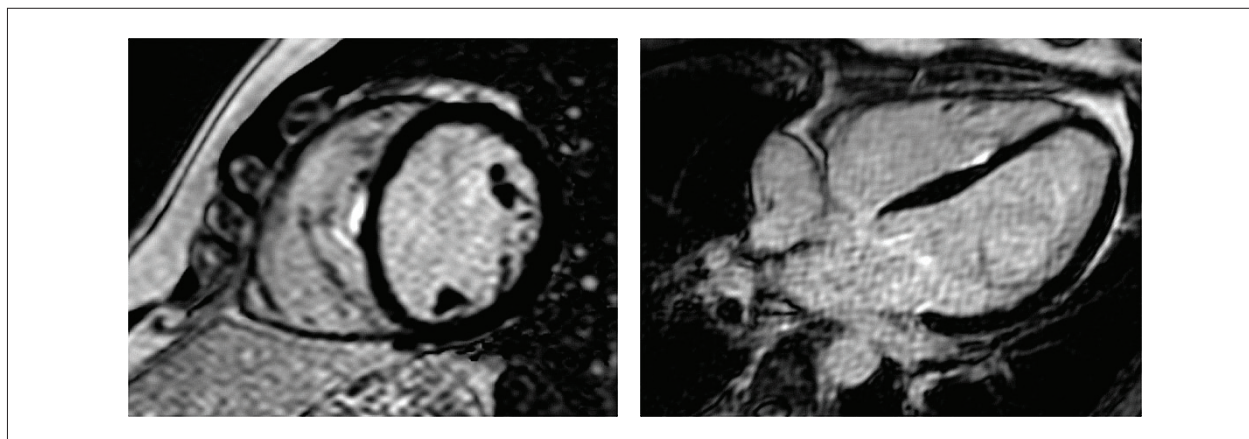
Magnetic resonance image of ventricular fibrosis in patient 7 (~0.6g).
